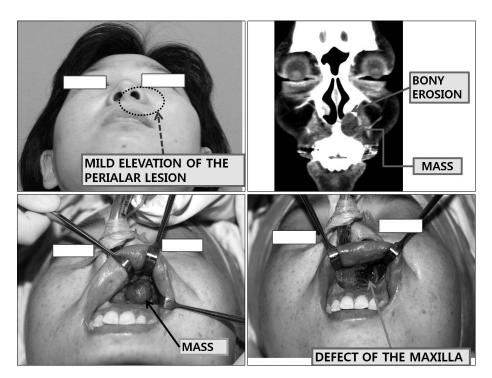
Case 5. A 35-year-old female. (Above, left) Mild elevation of left side peri-alar region. (Above, right) The facial CT sagittal view reveals a 1.5-cm round, cystic mass in the left anterior nasal floor with adjacent bony erosion. (Below, left) Intraoperatively, a well-marginated cystic mass is seen. (Below, right) After excising the cystic lesion under general anesthesia, a defect and erosion of the maxilla are seen intraoperatively.
